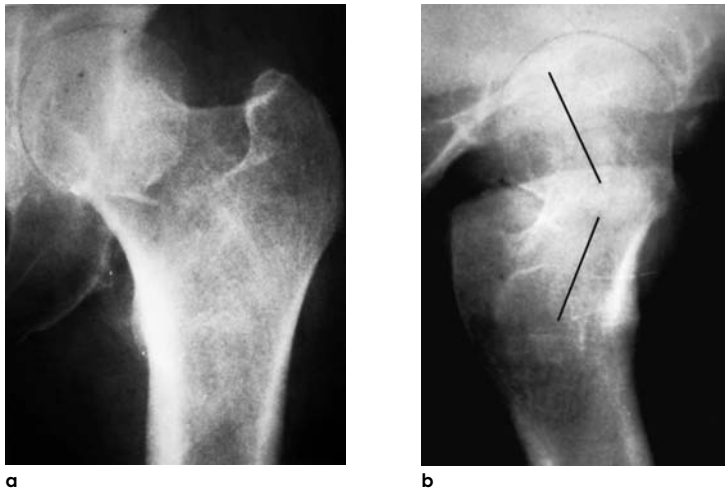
The importance of lateral radiographs.
